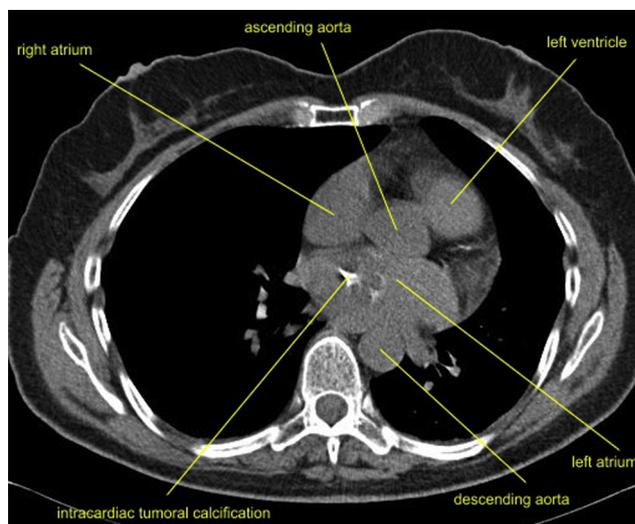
CT image before intravenous contrast administration with visible calcifications in a tumor mass.
